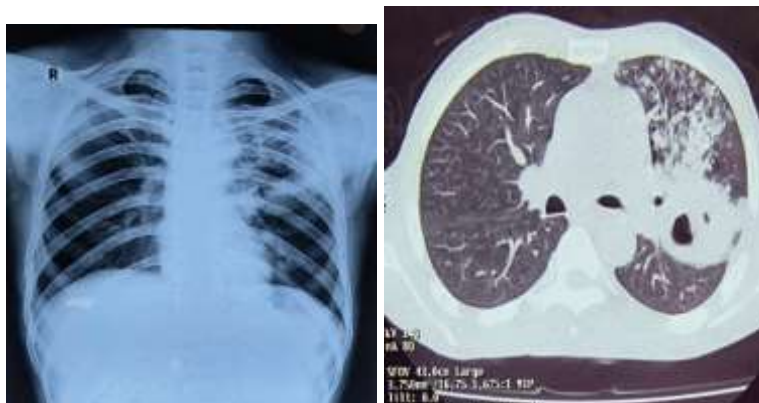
Chest X-ray showing bilateral infiltrative shadows on upper zone.
